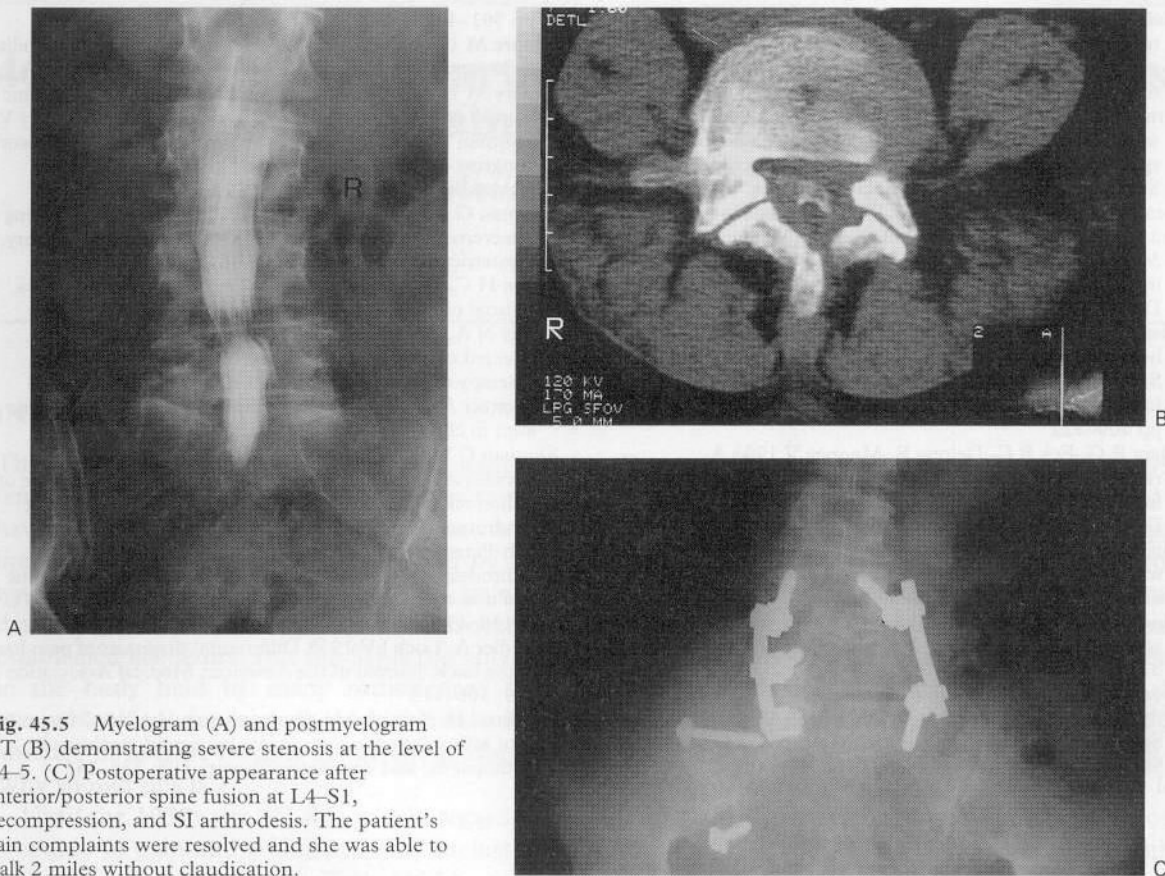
Myelogram (A) and postmyelogram CT (B) demonstrating severe stenosis at the level of L4-5. (C) Postoperative appearance after anterior/posterior spine fusion at L4-S1, decompression, and SI arthrodesis. The patient's pain complaints were resolved and she was able to walk 2 miles without claudication.
